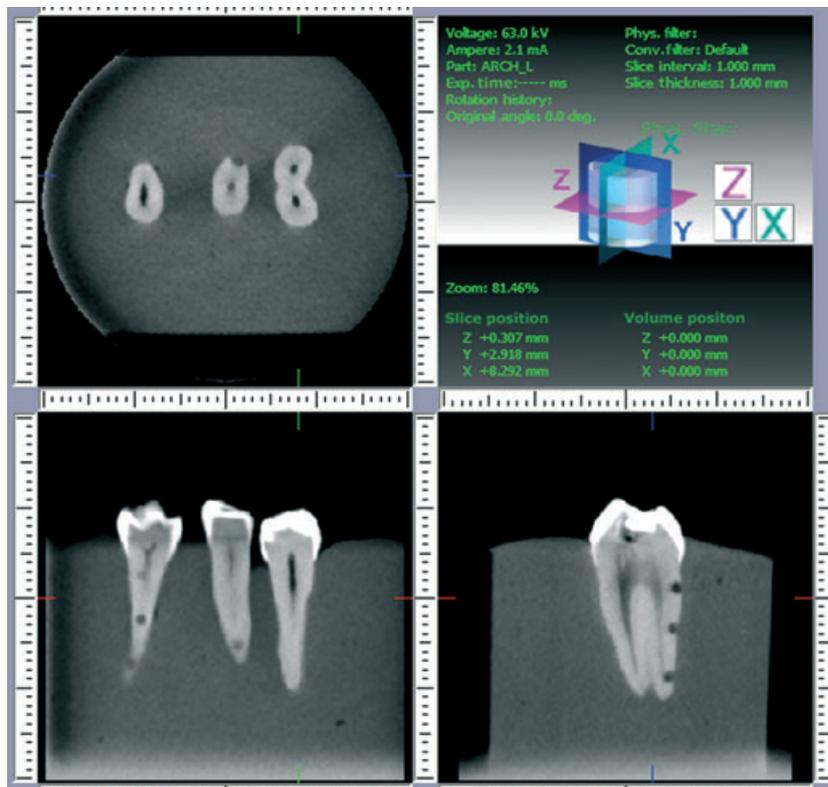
Slices obtained by cone beam computed tomography.
